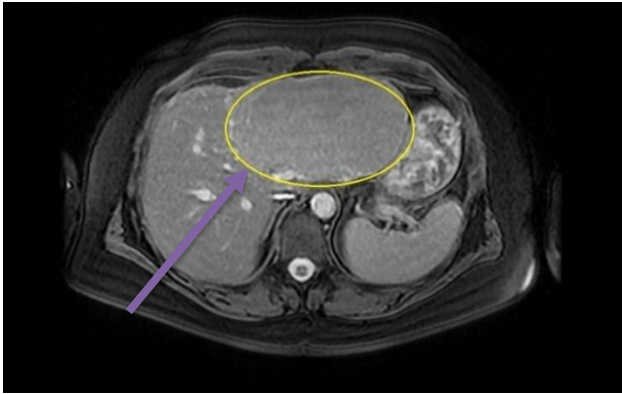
This CT scan shows the focal nodular hyperplasia in the left lobe of the liver.
